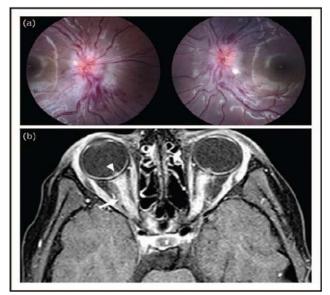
Images of a 7-year-old girl presenting with bilateral myelin oligodendrocyte glycoprotein-optic neuritis: (a) fundus photographs showing bilateral disc edema with multiple disc hemorrhages, (b) gadolinium enhanced MRI demonstrating bilateral, longitudinally extensive optic nerve enhancement with nerve sheath enhancement (arrow) and optic disc edema (arrowhead).
